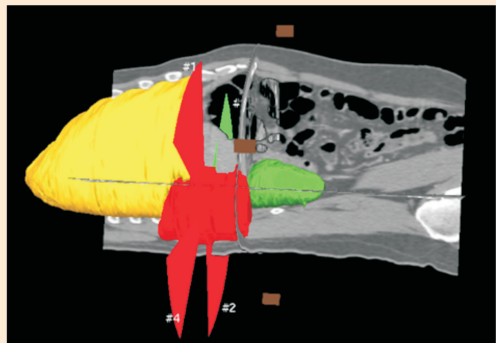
Fan Shaped Beam Planning with CT Images
